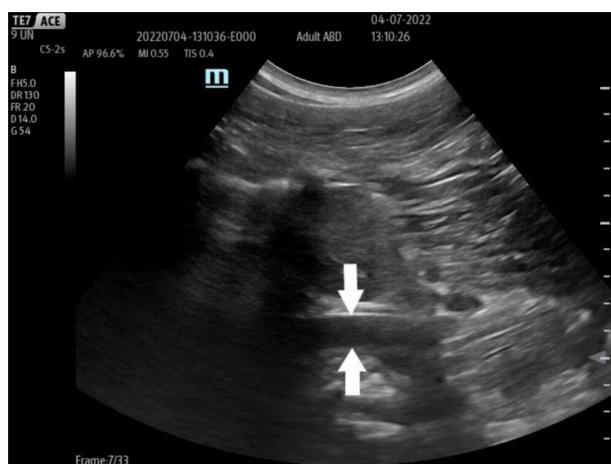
IVC ultrasound image with convex transducer (IVC indicated by arrows): B-mode ultrasound
